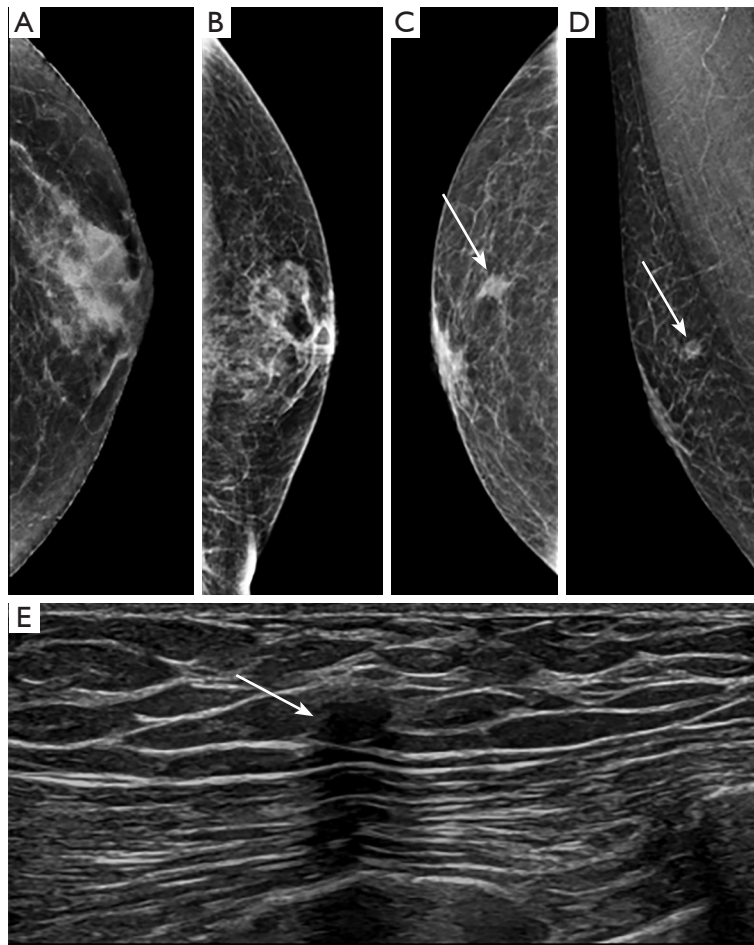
Mammographic and ultrasonographic images of breast mass. (A) Left breast craniocaudal image showing scattered areas of fibroglandular density without discrete mass. (B) Left breast mediolateral oblique view. (C) Right breast craniocaudal image, arrow pointing to small focal mass. (D) Right breast mediolateral oblique image, arrow pointing to small focal mass. (E) Ultrasonographic images of hypoechoic round right breast mass (arrow) with posterior acoustic shadowing measuring 0.5×0.4×0.5 cm corresponding to mammogram at 9:00, 1 cm from the nipple with slightly indistinct margins.
